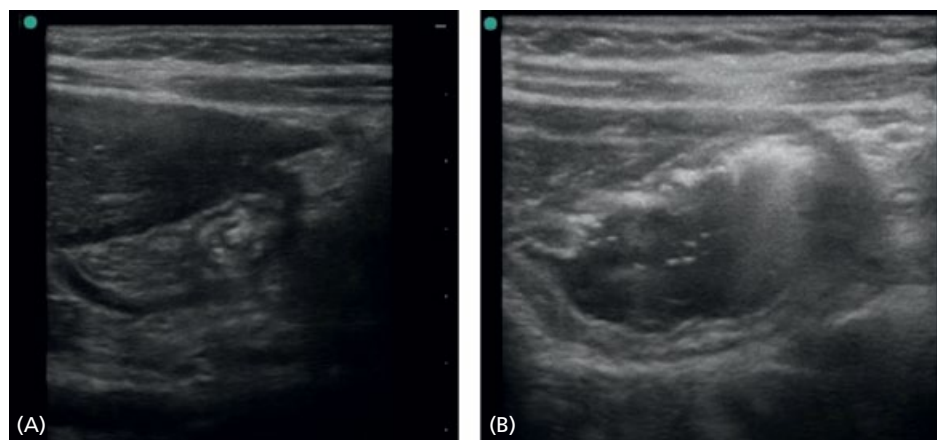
Gastric ultrasound to assess fluid presence and content. (A) Empty collapsed gastric antrum. (B) Full gastric antrum with mostly anechoic fluid content. Source: Reproduced from Gagey et al [260] with permission of Elsevier.
